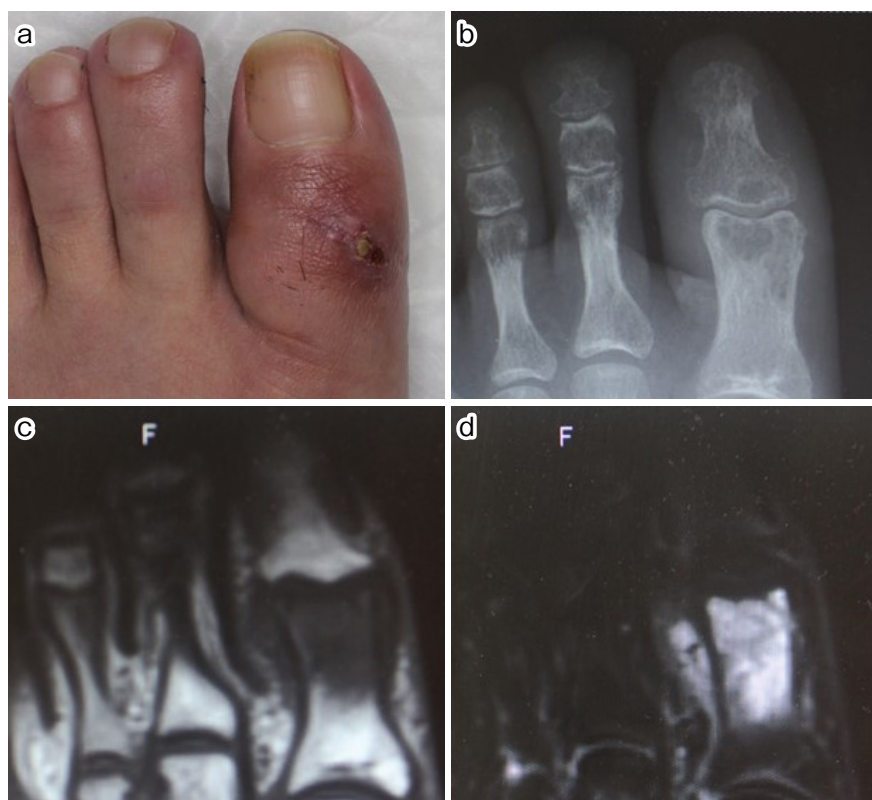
Initial examination findings. a: There was scarring at the interphalangeal (IP) joint of the left first toe. b: No abnormal findings were also observed on X-ray.
